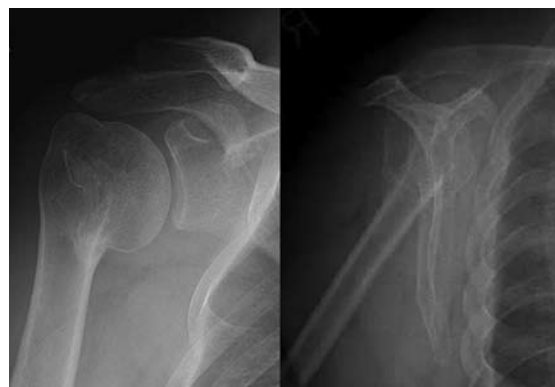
Repeat (a) anteroposterior and (b) Y-scapular view radiographs taken 15 months postoperation show union of the humeral head fracture. Range of motion was good with forward flexion 170°, external rotation 80° and internal rotation up to the tenth thoracic vertebra level.
